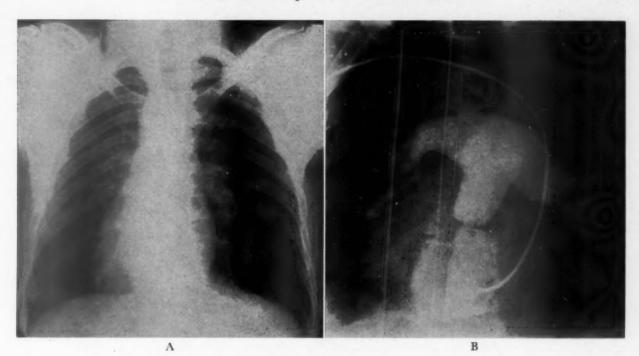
A, roentgenogram of thorax showing dextrocardia and right aortic arch. Note malformations of left first and fourth ribs. B, selective angiocardiogram obtained during cardiac catheterization. An opaque catheter can be seen coursing from a right antecubital vein via the innominate and left superior vena cava and left atrium into the physiologic right (venous) ventricle. Radiopaque dye is seen partially filling the ventricle and pulmonary arteries. The ventricular septum is intact. Note the absence of coarse trabeculation and crista supraventricularis in the ventricle and the extreme narrowing at the usual level of the pulmonary valve. This more caudal and medial location of the pulmonary valve area is characteristic of congenital corrected transposition. Poststenotic dilatation of the pulmonary artery also is apparent.
